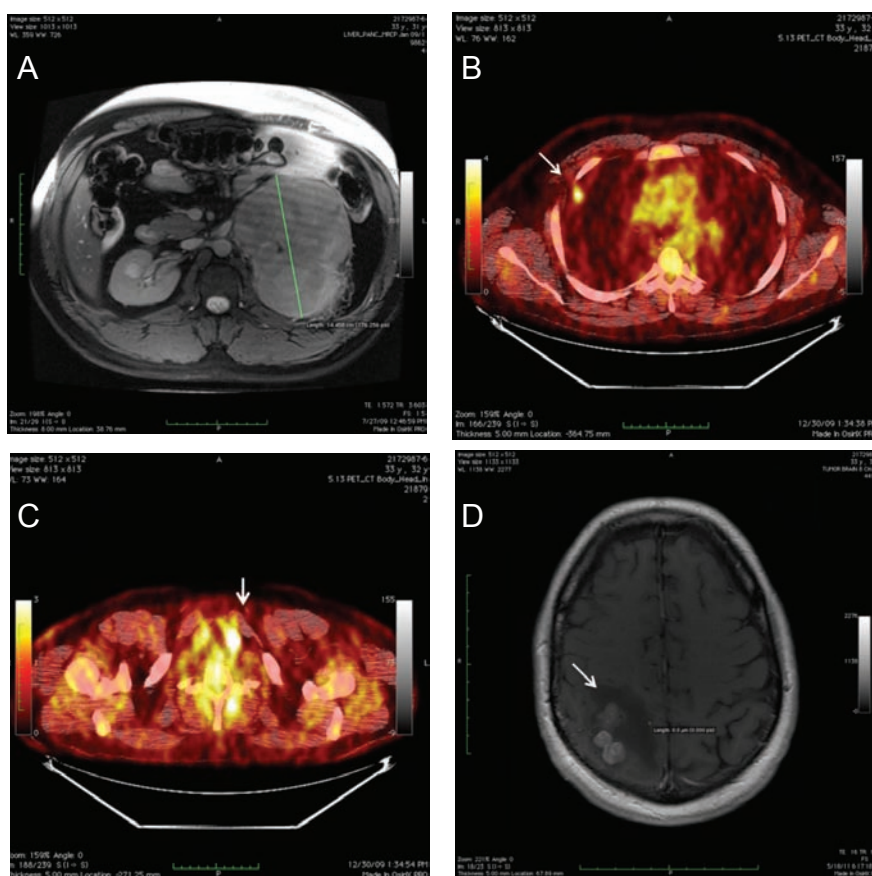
A) Left adrenal mass, MRI; B) Right upper lobe pulmonary nodule, PETCT Scan; C) Thyroid nodule, PETCT Scan; D) R parietal brain metastases and associated edema, MRI with contrast.
